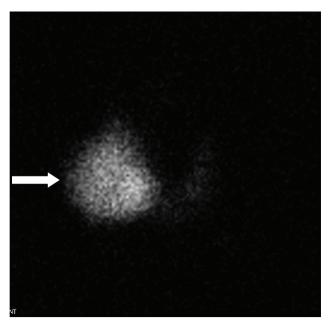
Thyroid scintigraphy showing a dominant "hot" nodule on the inferior right lobe with relative suppression of the uninvolved gland.
